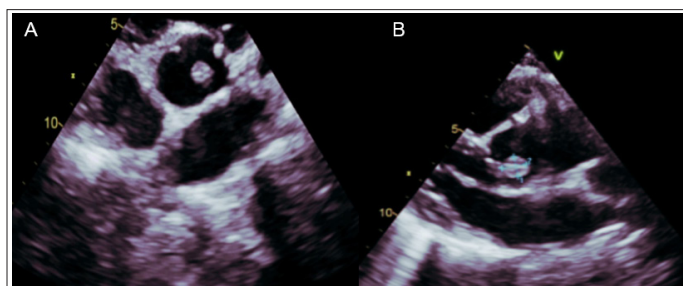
Transthoracic echocardiography showing a round well defined mass on the aortic valve
